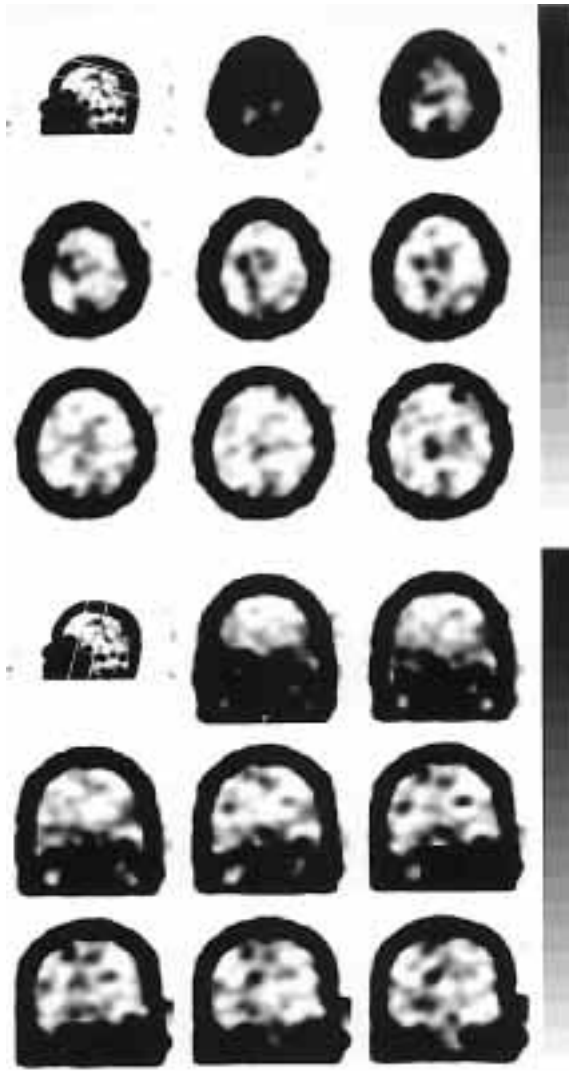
^{201}Tl scintigraphy of the head obtained on January 31. Abnormal accumulation was noted in the right frontal and parietal lobes and the left frontal lobe.
